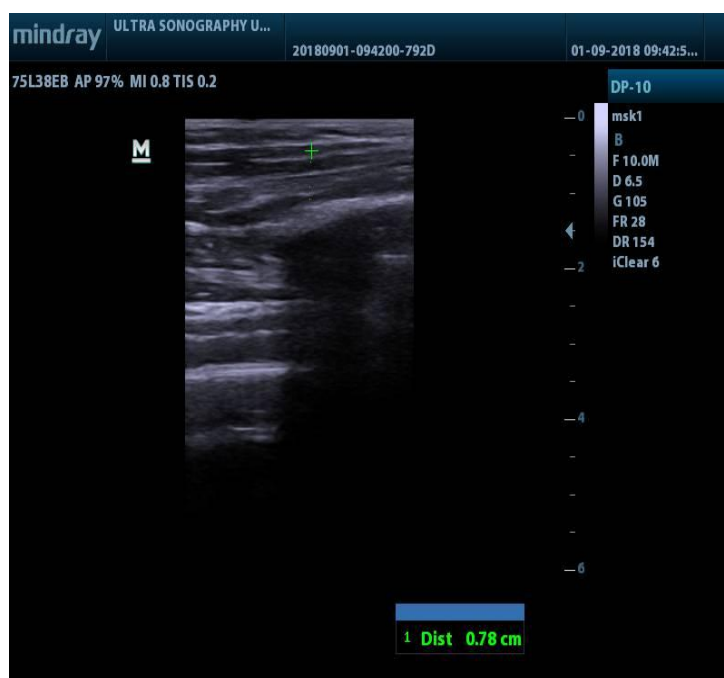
Measurement of muscle thickness of biceps muscle by ultrasonography.
